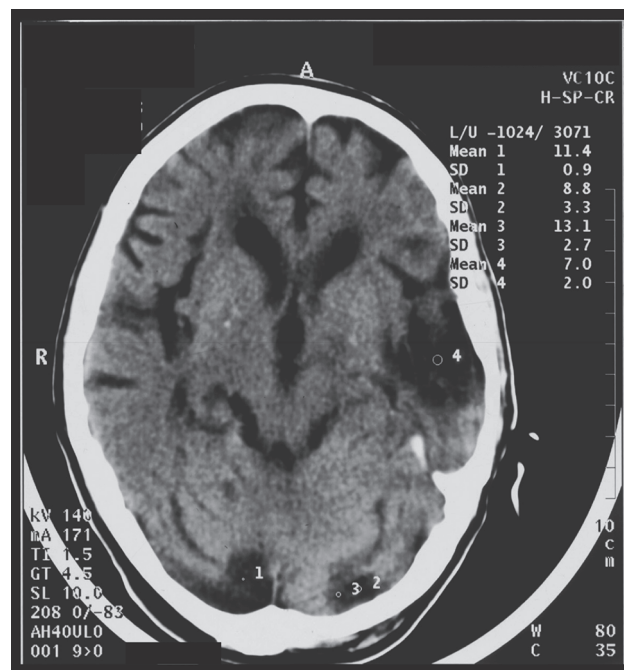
Patient's computed tomography (CT) brain scan on presentation; 4 foci visible marked 1, 2, 3 and 4.
